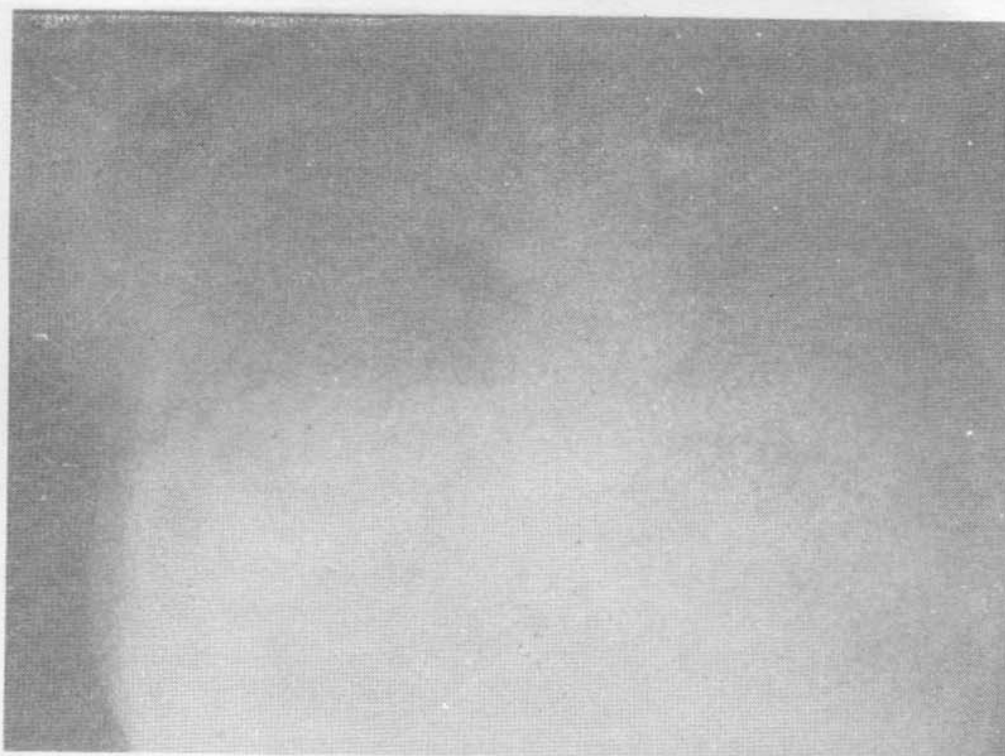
X-ray showing diffuse calcific densities.
